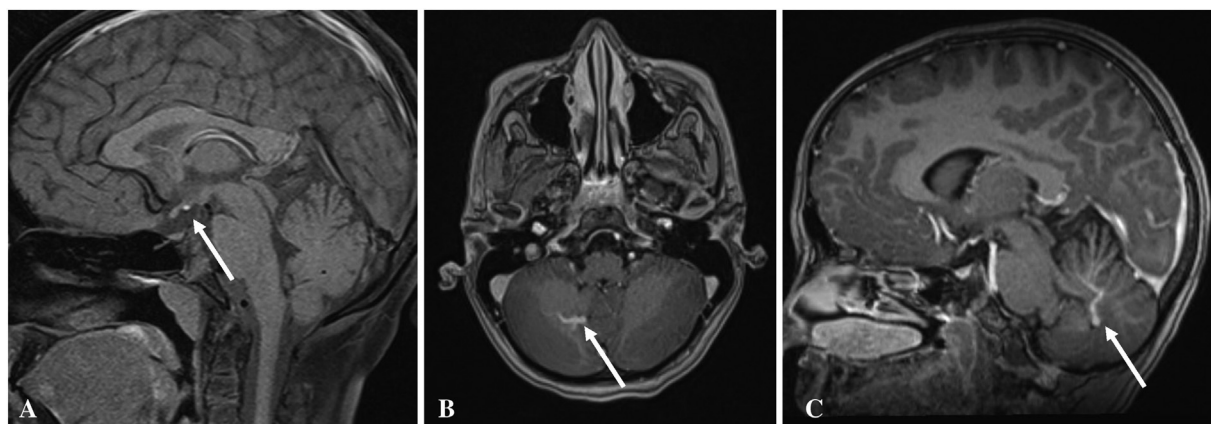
A 32-year-old female patient presented with infertility. Luteinizing hormone (LH), follicle-stimulating hormone (FSH), and mild growth hormone deficiency was found. Sagittal magnetic resonance imaging (MRI) image demonstrating ectopic T1-weighted (T1W) bright spot, located at the median eminence and postcontrast axial and sagittal T1W images showing developmental venous anomaly.
